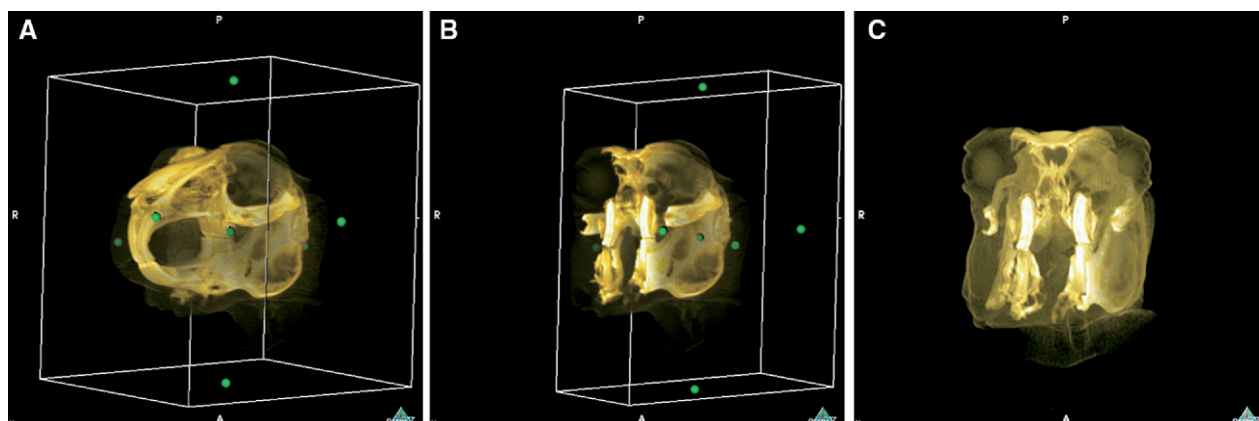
The 3D volume rendering format is used to visualize an entire block of tissue or body part, such as the head. To make volume rendering more representative of actual organ structure, the tissues that are not of interest are deleted, enhancing the tissues of interest. High-speed computers allow the image to be rotated in any direction. Volume rendering is most effective when only a few tissues or structures are represented. Presently, it is the most useful reconstructive method in CT; however, it should only be used in conjunction with transverse gray scale images because it is only a representation of the actual data set (A). Movement of a single side effectively crops away that aspect of the 3D image, allowing visualization of inner anatomical structures (B). A volume rendering cropped at the level of the cheek teeth shows the axial section of a severe osteomyelitic area of the right mandible (C). Reprinted from: Capello V, Lennox A: Clinical Radiology of Exotic Companion Mammals. Wiley-Blackwell Publishing (2008), with permission.
